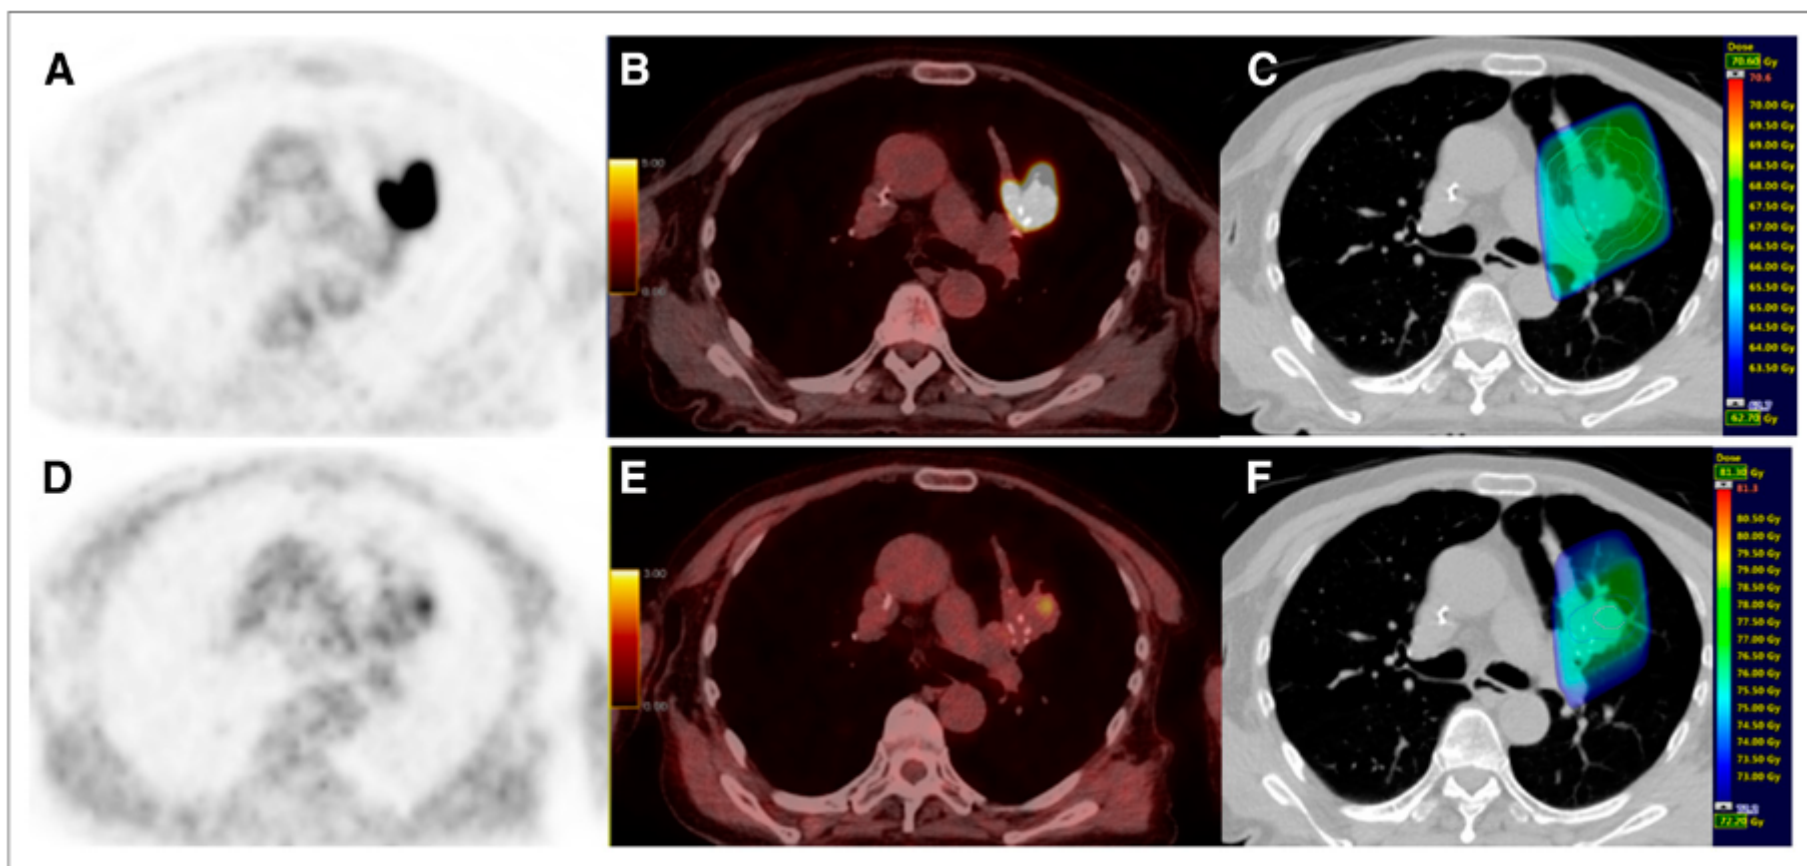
Example of patient with upper left lung NSCLC: ^{18}F -FDG (A); ^{18}F -FDG PET/CT (B); planning radiotherapy based on ^{18}F -FDG (66 Gy) with BTV_m (gross tumor volume), CTV, and PTV (C); PET ^{18}F -FMISO (D); ^{18}F -FMISO PET/CT (E); and boost based on ^{18}F -FMISO PET (76 Gy) with BTV_n and PTV boost (F).
